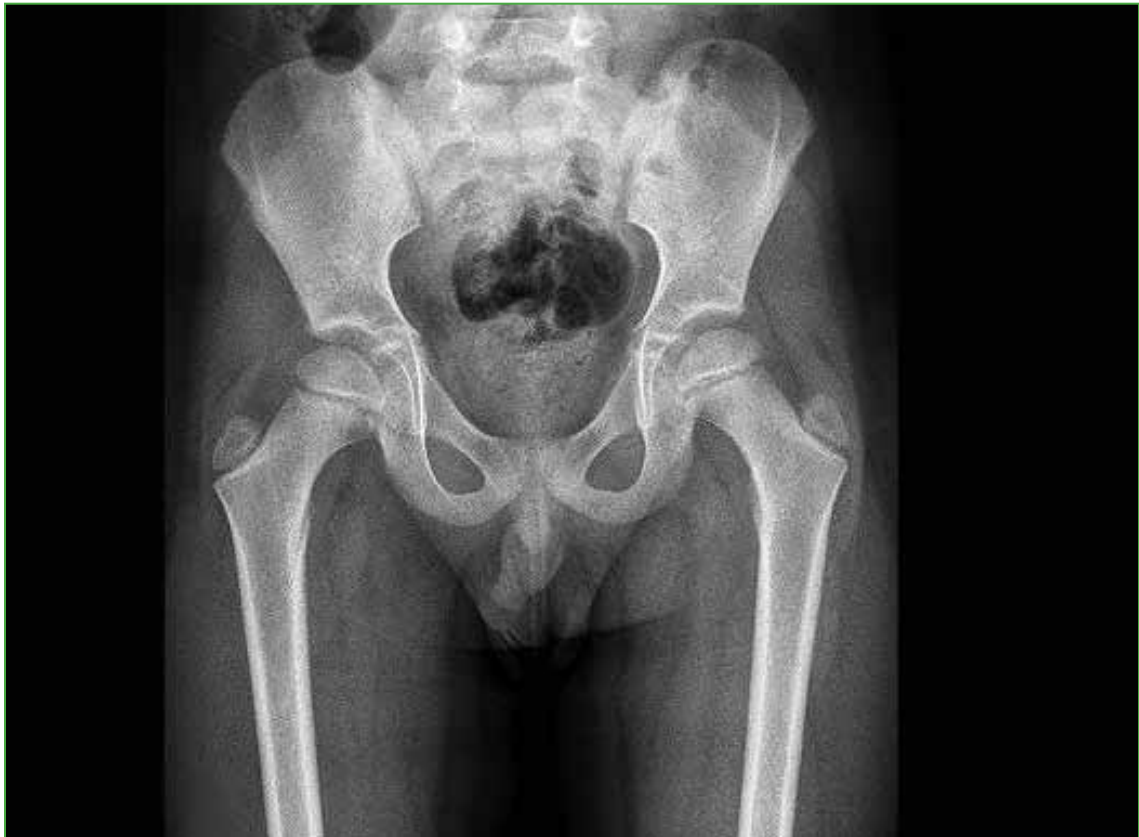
Anteroposterior radiograph of the hip at 6 months of evolution. There are no signs of bone compromise.
